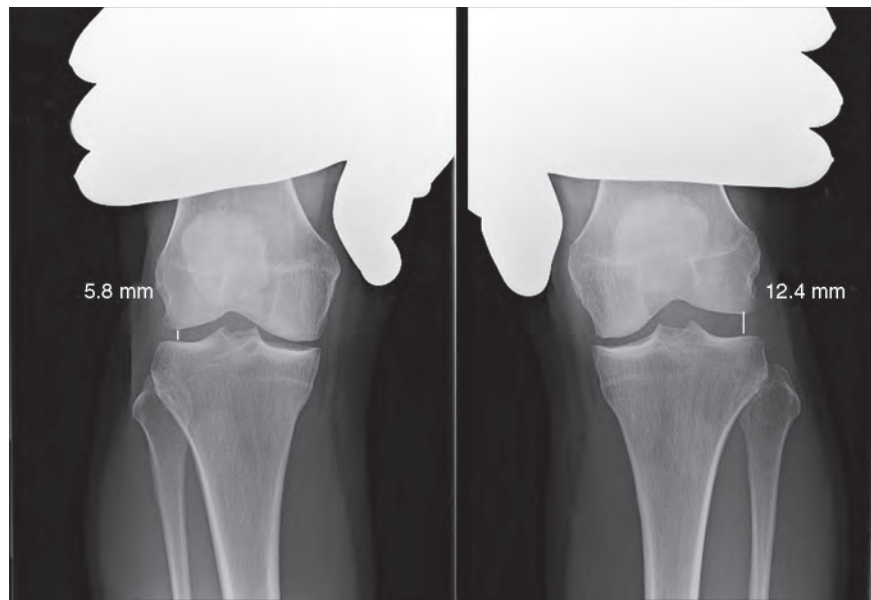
Varus stress radiographs demonstrating a 6.6 mm side-to-side difference in lateral compartment gapping, which is indicative of a complete grade III posterolateral corner injury.
